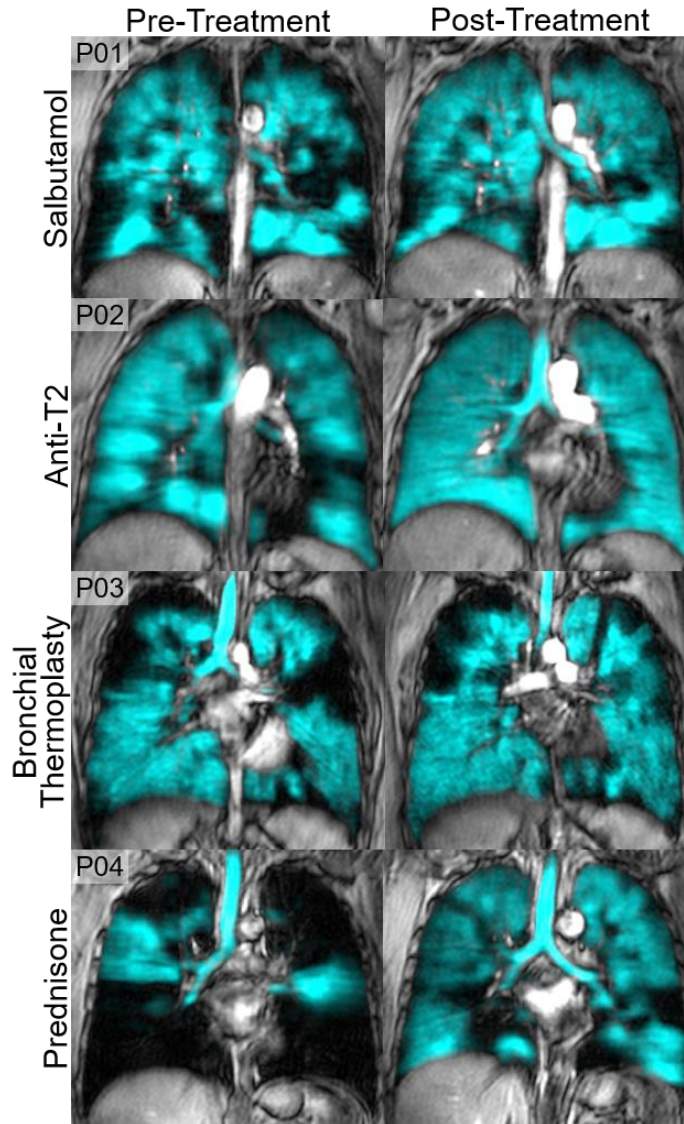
^{129}Xe MRI Ventilation Pre and Post-Treatment in Asthma
